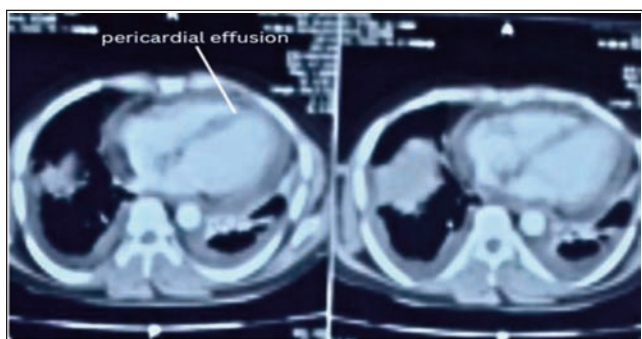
CT scan showing pericardial effusion (Figure 2). Large volume pericardial effusion was confirmed on echocardiography.
